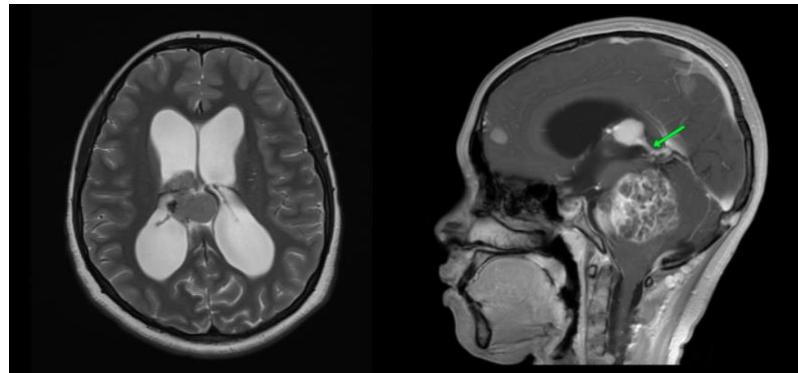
MRI showed hypointense mass in T1WI (A and E), isointense mass in T2WI (B and F), blooming artifacts in SWI (C), T1+ Contrast showed enhanced mass, dural tail sign (green arrow) (D and G).
